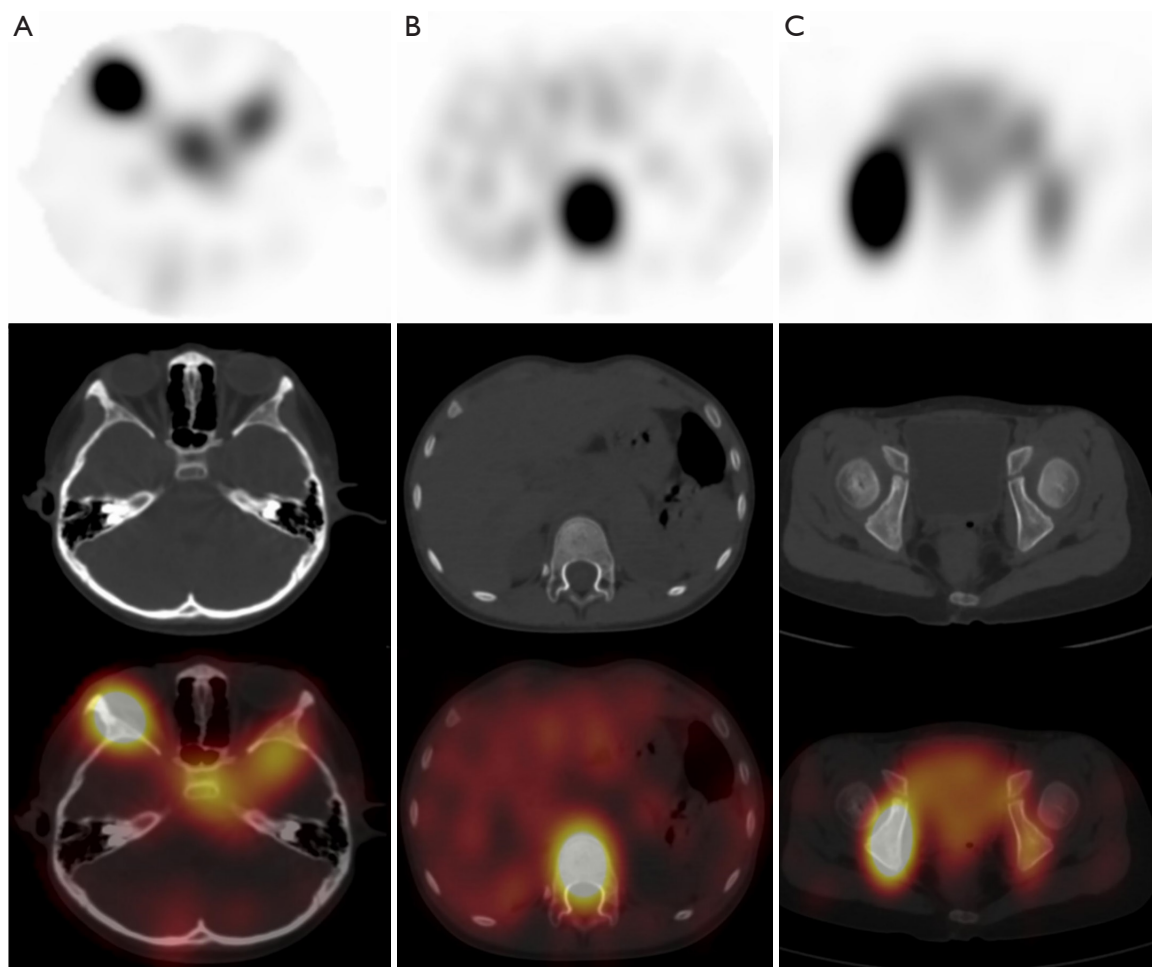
Representative ^{123}I -MIBG xSPECT/CT images of a patient with positive bone metastasis results. In a 7-year-old girl diagnosed with NB in the left adrenal gland, xSPECT/CT revealed enhanced contrast uptake in the lateral wall of the orbit (A), spine (B) and pelvis (C). The larger one in the right iliac bone corresponded to the SUVmax, SUVavg, SUVmin, and SUVpeak values of 9.34, 7.48, 4.99, and 8.98 respectively; subsequently confirming the presence of bone metastasis. ^{123}I -MIBG, ^{123}I -metaiodobenzylguanidine; xSPECT/CT, single-photon emission computed tomography/computed tomography; NB, neuroblastoma; SUVmax, maximum standardized uptake value; SUVavg, average standardized uptake value; SUVmin, minimum standardized uptake value; SUVpeak, peak standardized uptake value.
